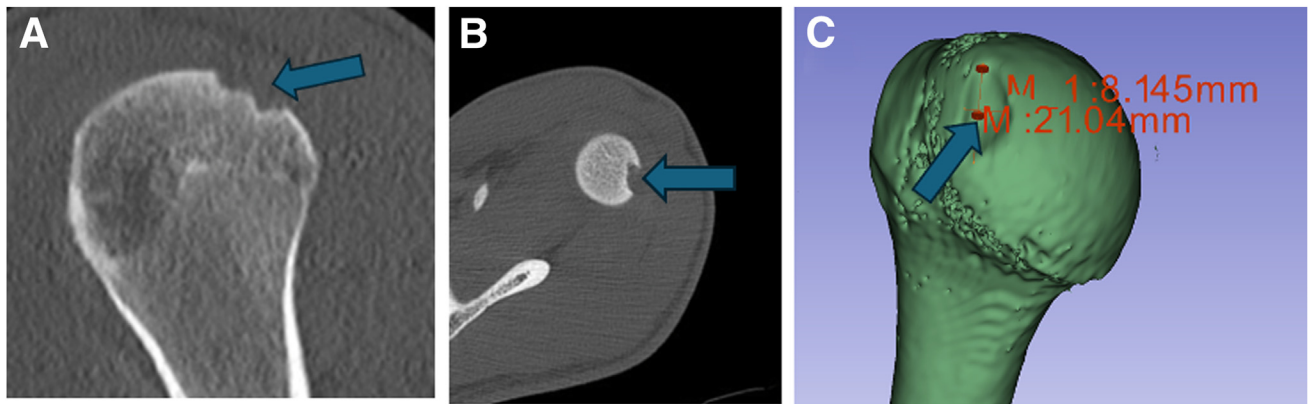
Preoperative computed tomography scan of the left shoulder further characterizing posterolateral humeral head bone loss on sagittal (A), axial (B), and 3-dimensional reconstruction (C) views. Arrows are pointed towards the Hill-Sachs lesion.
